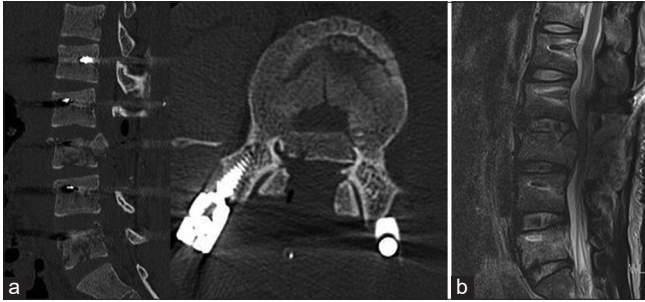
Postoperative CT (a) scan and MRI (b) demonstrated a slight ventral shift in the protruded bone fragment ventrally with acceptable decompression of the dural sac.
